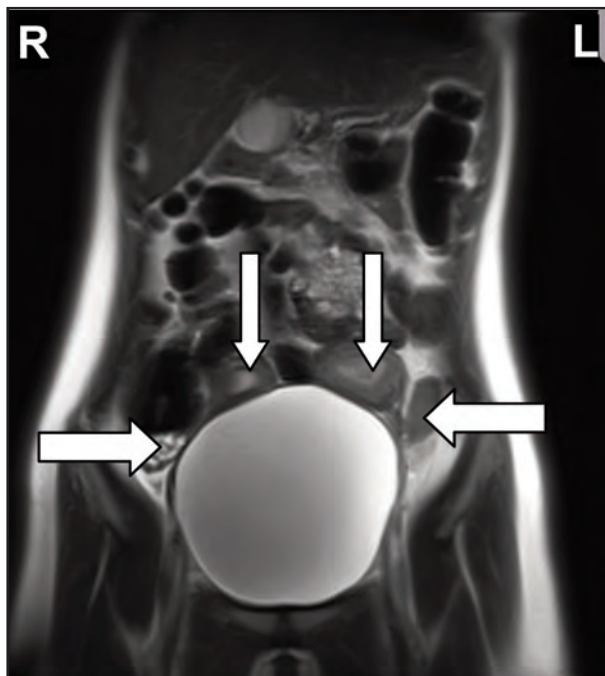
Coronal T2WI MRI shows two separate uterine cavities (thin arrows) with normal right ovary and left endometrioma (thick arrows)
